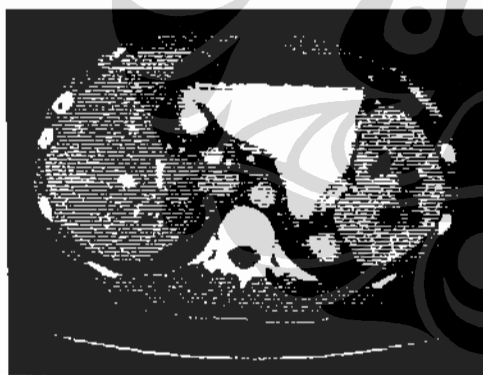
CT scan of the abdomen showing multiple focal hypodens lesions in the spleen
